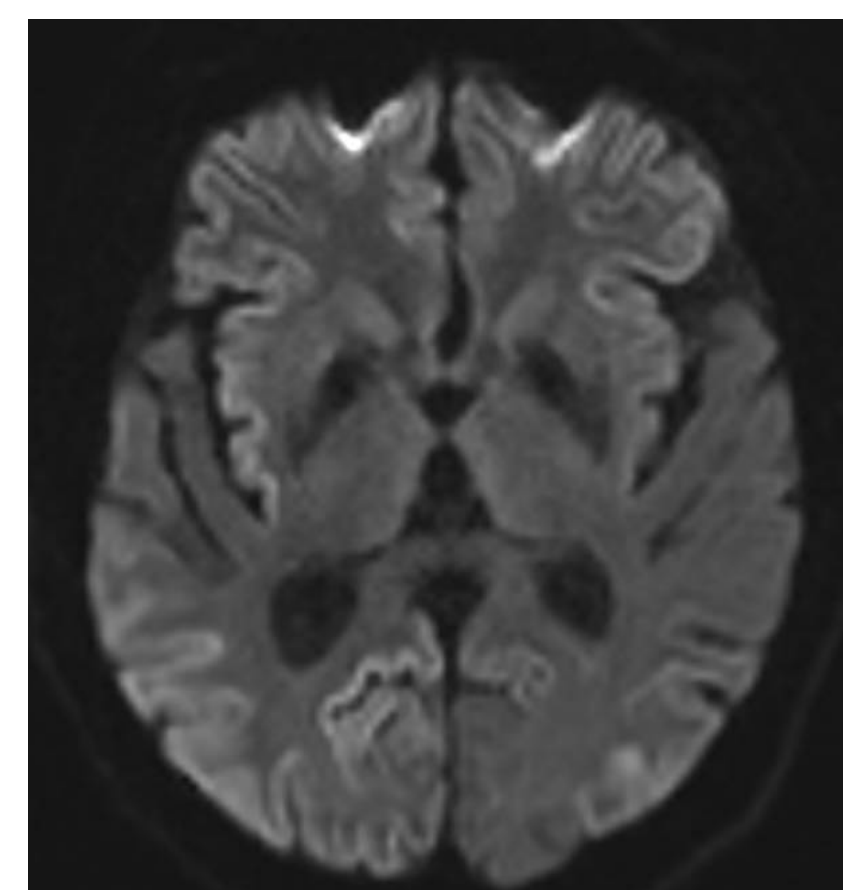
Axial diffusion-weighted MRI showing typical changes of sCJD with high signal in the cortical ribbon and striatum
